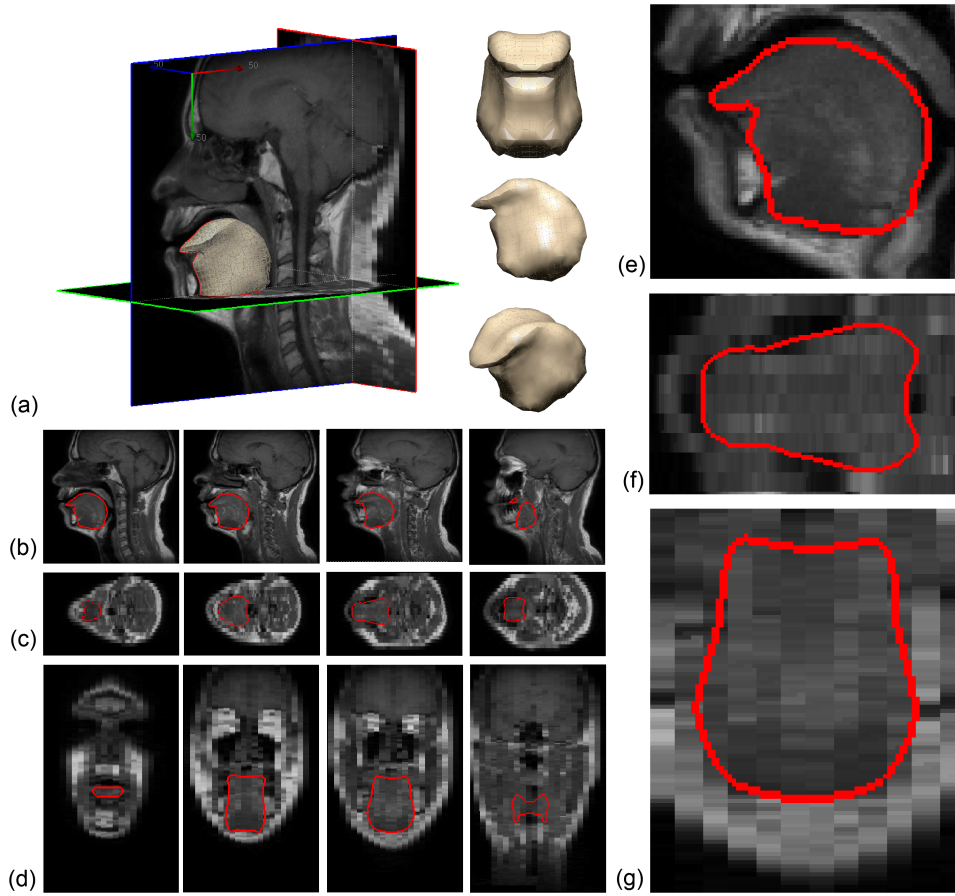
Mesh derived tongue contours superimposed on the MR image: (a) 3D subject-specific FE tongue mesh (Normal #1), (b) Sagittal views (mid-sagittal to the lateral side), (c) Axial views (inferior to superior), (d) Coronal views (anterior to posterior), (e) enlargement of the tongue region in a sagittal slice, (f) enlargement of the tongue region in the coronal slice, (g) enlargement of the tongue region in an axial slice.
